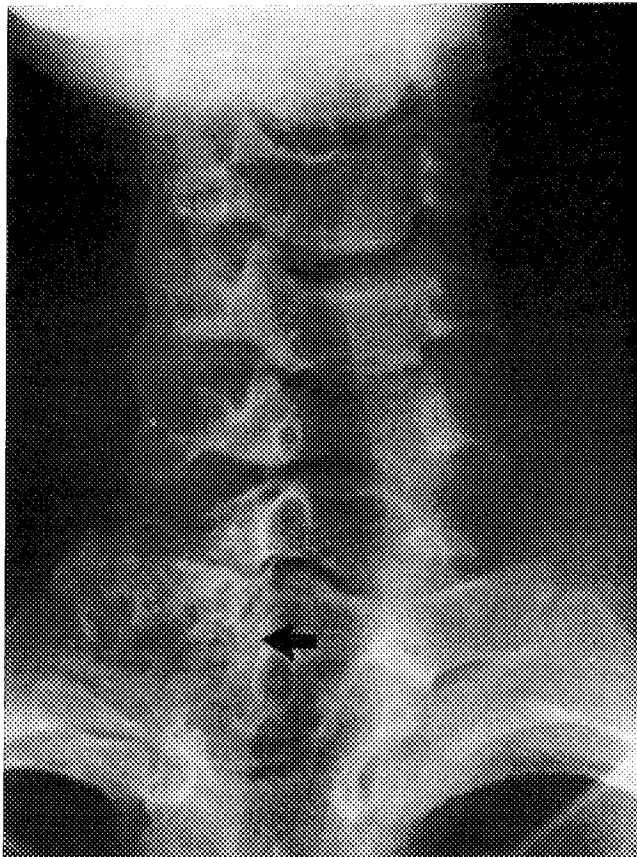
Roentgenogram of the cervical spine demonstrating a 4 X 4 cm irregular, sclerotic and lytic mass (arrow) extending lateral and superior from the right side of the T1 vertebral body.
